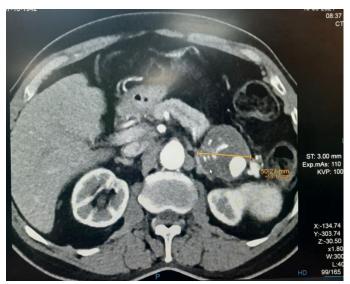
Axial view of CT mesenteric angiogram showing a 50.27mm splenic artery aneurysm
